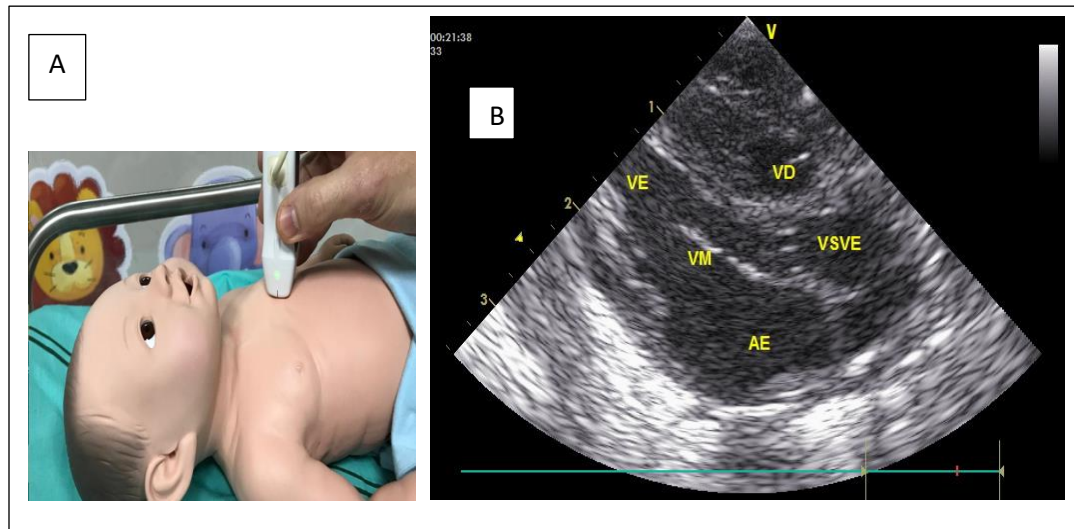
Long axis parasternal window. A) Positioning of the transducer with the marker directed towards the right shoulder. B) Image of the heart chambers. LA: left atrium, RV: right ventricle, LV: left ventricle, MV: mitral valve, LVOT: left ventricular outflow tract.
